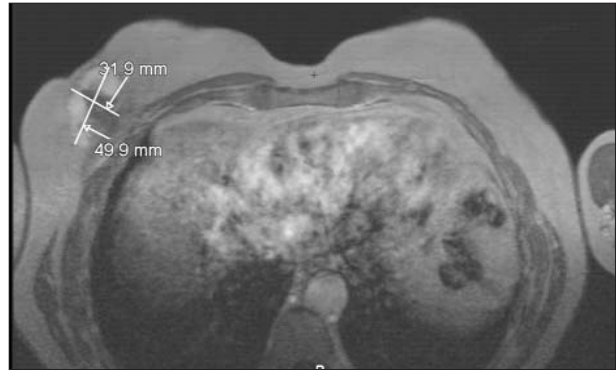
Measurements on transverse MRI
